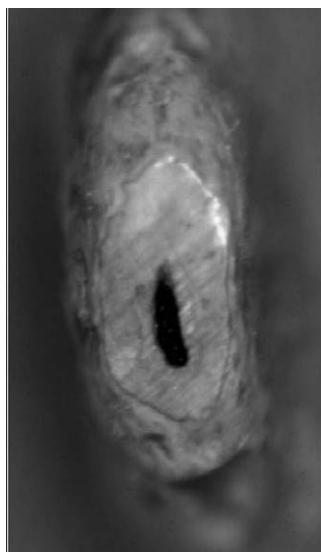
Cross-section of a mandibular first premolar, indicating a long-oval and irregular root canal. In the same tooth, the faciolingual direction of the routine radiograph may be mistakenly recognized as a round-shaped canal because a mesiodistally directed radiograph is rarely available clinically.
